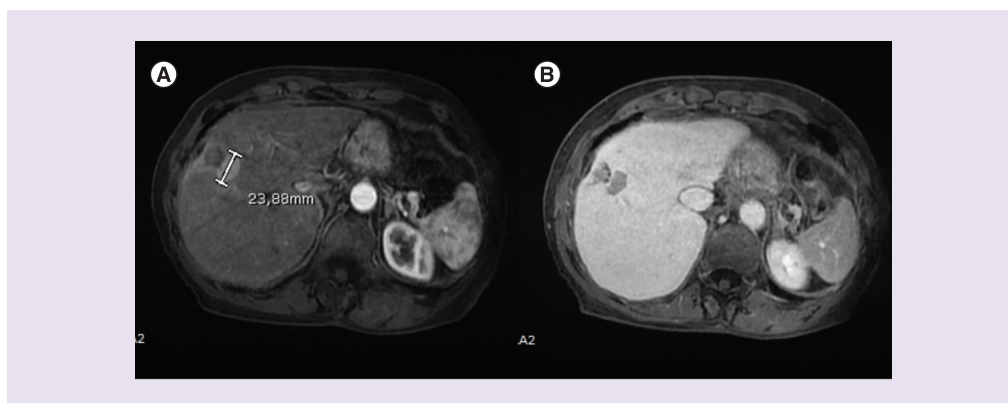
Example of Liver Imaging Reporting and Data Systems treatment response assessment. MRI showing a tissue adjacent to a thermal ablated lesion featured by arterial phase iperenhancement (A) and delayed phase wash-out appearance (B), meeting the criteria for Liver Imaging Reporting and Data Systems treatment response viable.
